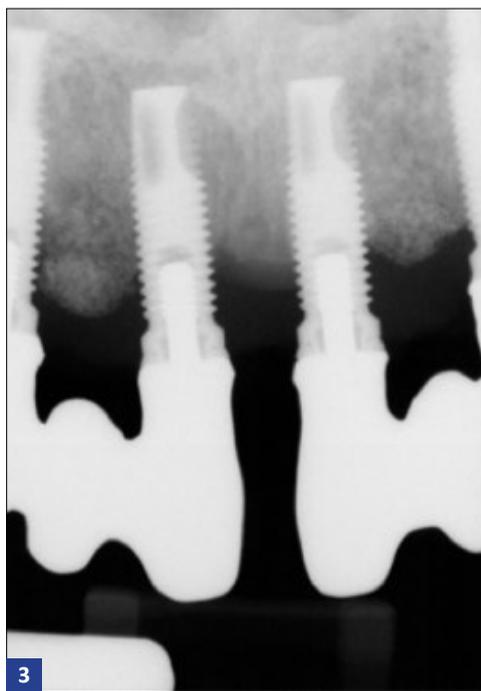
and Fig 4. Radiographs showing bone loss around an implant.
